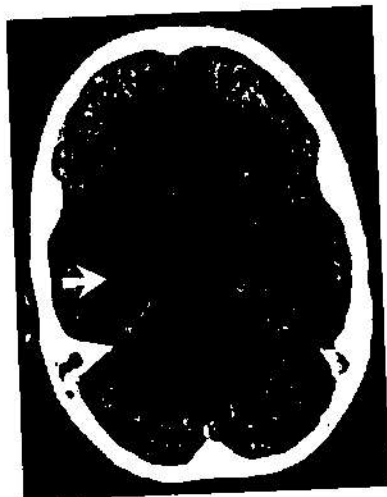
Cranial CT of a 7-year-old girl demonstrating dilated fourth ventricle and severely enlarged cerebellar sulci. The tips of the temporal horns (arrow) are slightly dilated.
